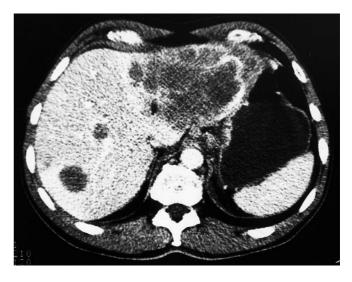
Computed tomography of the abdomen, revealing a multi-locular hepatic tumour measuring 10.8×7.2 cm in maximum diameter
